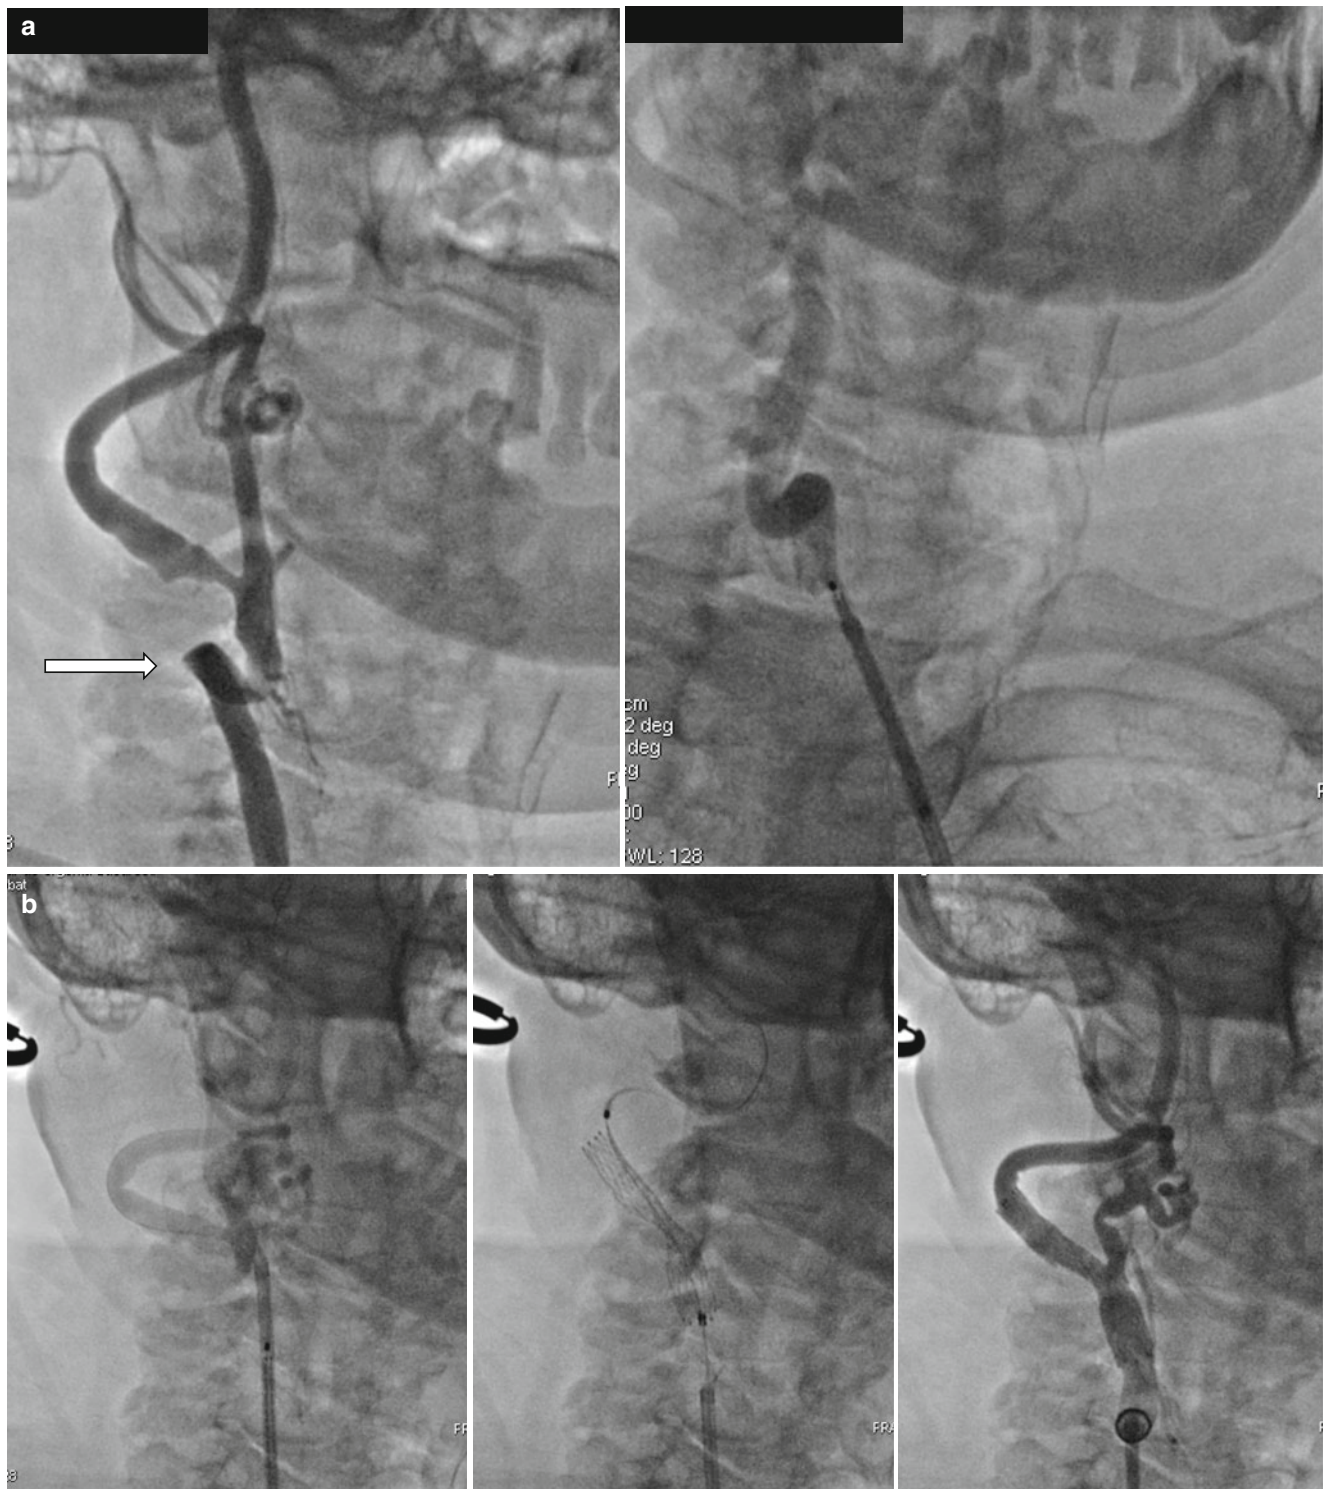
Excessive kinking (*white arrow*) of the CCA and ICA – and CAS. Angiography offers a dynamic picture of the carotid bifurcation (over the CT-angio or MRA) and of the possibility of performing the CAS or not in selected patients. Panel (a): excessive kinking of the CCA that theoretically (and especially after CT-angio or MRA) would
